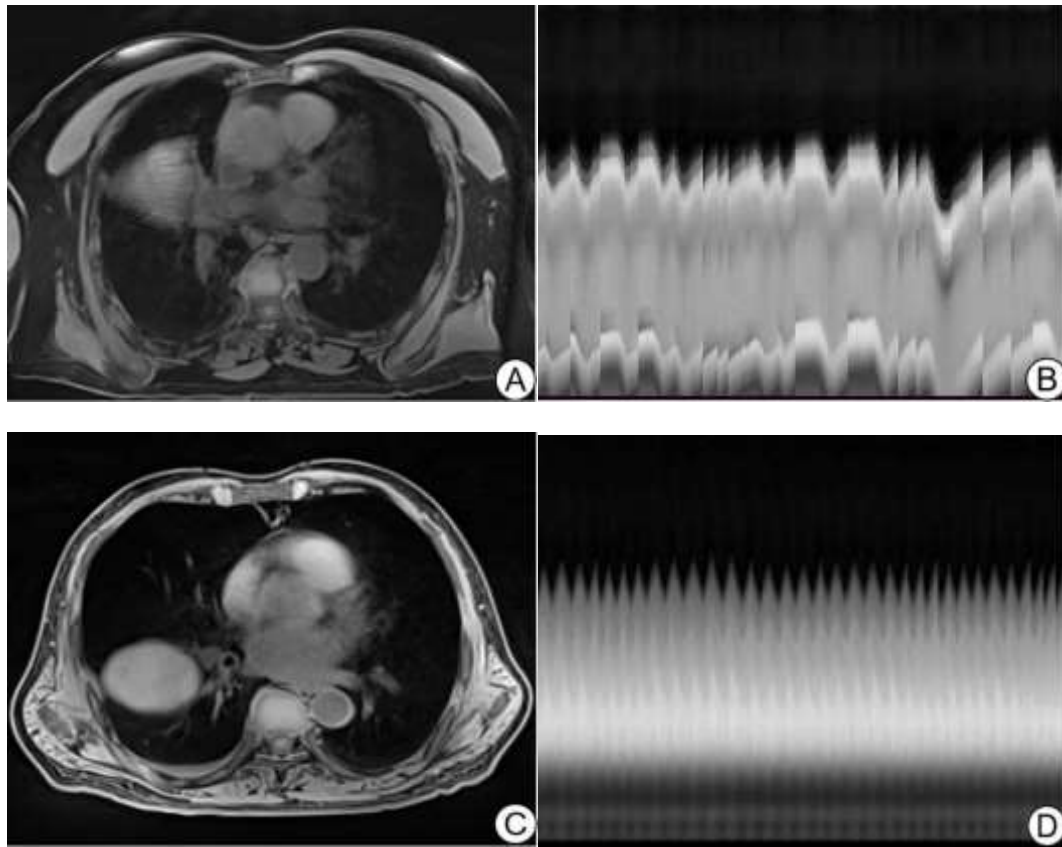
A 69-year-old male who did not undergo breath training, irregular breathing (B), and MRI star VIBE image (A) showed substantial motion artifacts and indistinct lesion boundaries. In contrast, a 71-year-old man breathed regularly after breath training, and star VIBE images showed clear boundaries of the lesions (C, D).
